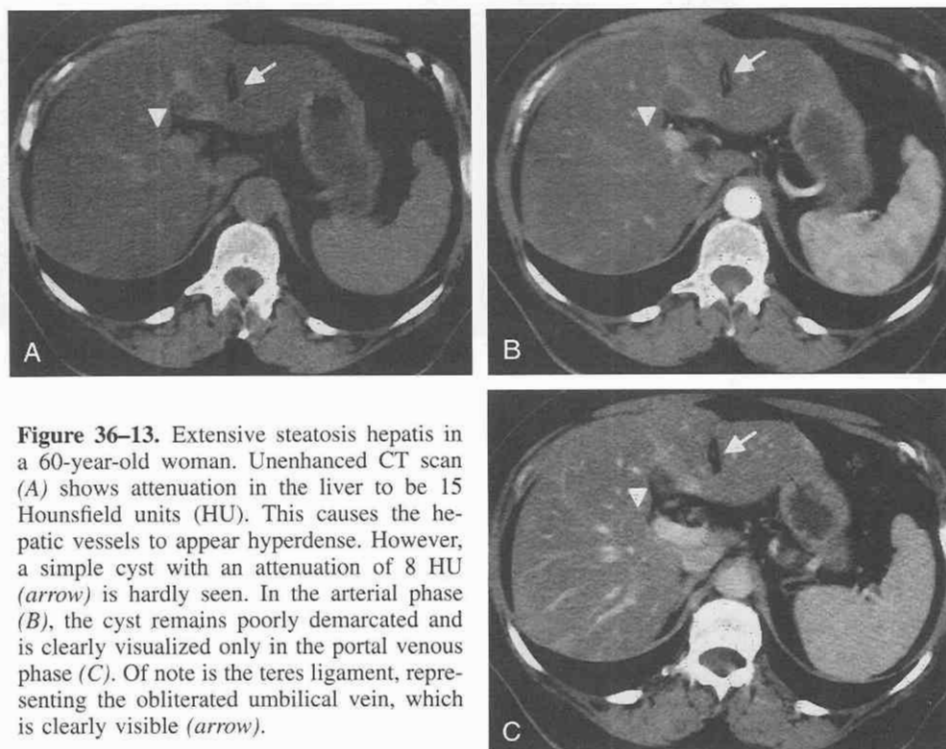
Extensive steatosis hepatis in a 60-year-old woman. Unenhanced CT scan (A) shows attenuation in the liver to be 15 Hounsfield units (HU). This causes the hepatic vessels to appear hyperdense. However, a simple cyst with an attenuation of 8 HU (arrow) is hardly seen. In the arterial phase (B), the cyst remains poorly demarcated and is clearly visualized only in the portal venous phase (C). Of note is the teres ligament, representing the obliterated umbilical vein, which is clearly visible (arrow).
